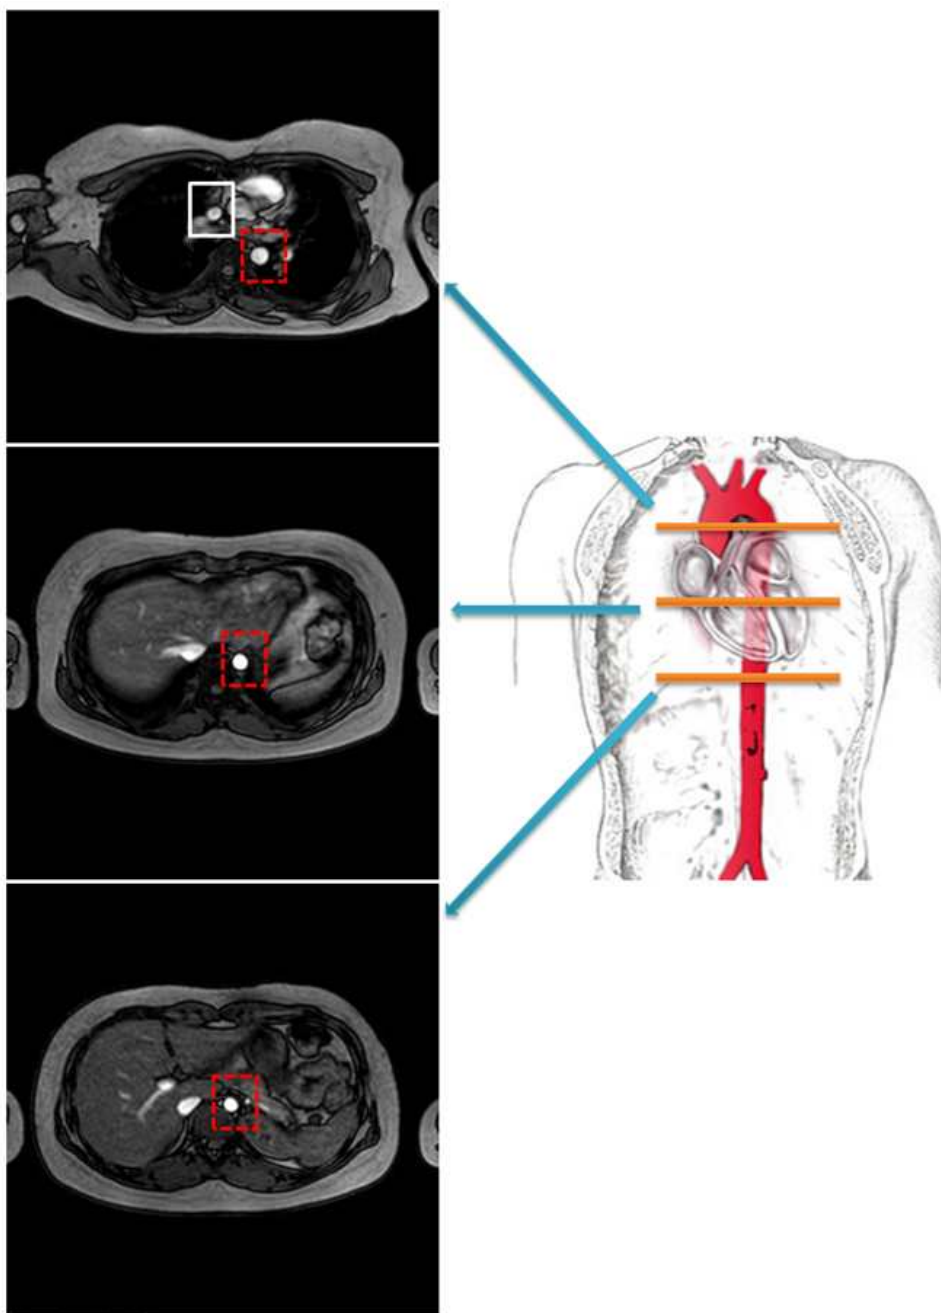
MR image samples and the three different positions of aorta
